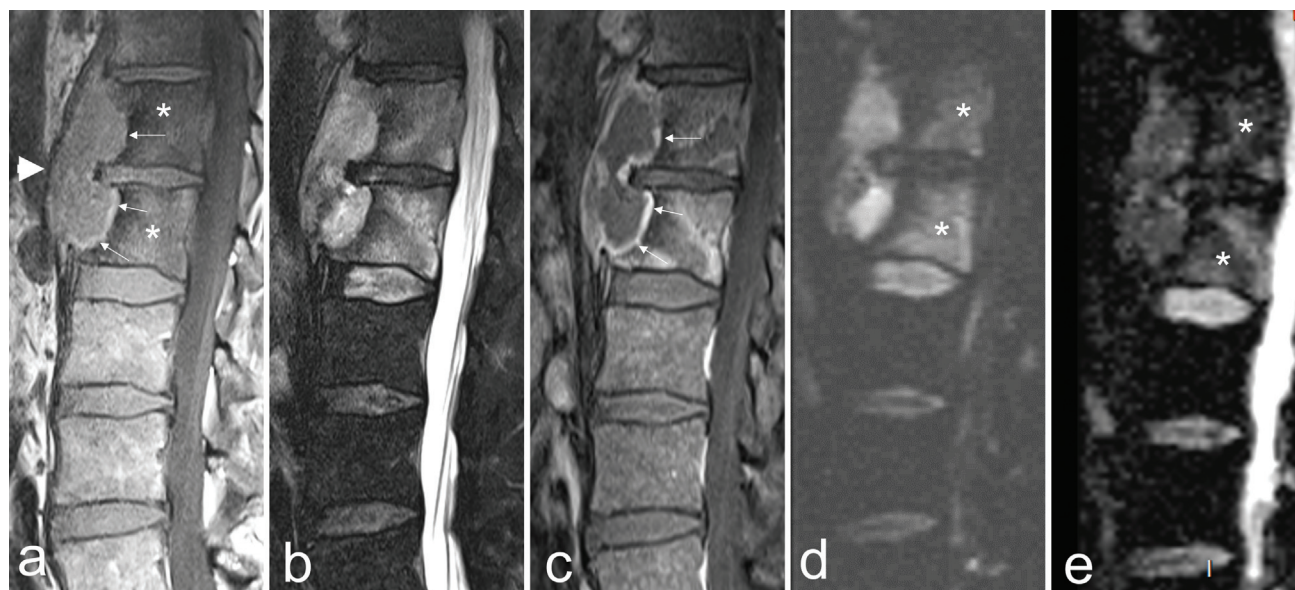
A 53-year-old man with fever and back pain and suspicion of spondylodiskitis on computed tomography (CT) (not shown). Sagittal (a) T1-weighted, (b) fat-suppressed T2-weighted, (c) contrast-enhanced T1-weighted, (d) diffusion-weighted image (DWI) ($b = 500$), and (e) corresponding apparent diffusion coefficient (ADC) map show marrow replacement of T2 and L1 vertebral bodies, restricted DWI (asterisks) with an ADC value of $0.58 \times 10^{-3} \text{ mm}^2/\text{s}$, a peripherally enhancing prevertebral collection with restricted DWI, causing scalloping of the anterior vertebral wall (thin arrows) and elevation without disruption of the anterior longitudinal ligament (a, arrowhead). The differential diagnosis included tuberculous spondylitis and lymphoma. The patient was diagnosed with Hodgkin's lymphoma on biopsy and positron emission tomography/computed tomography (not shown). There is an overlap of ADC values between malignant and infectious lesions, making the differentiation difficult based on quantitative imaging alone.
